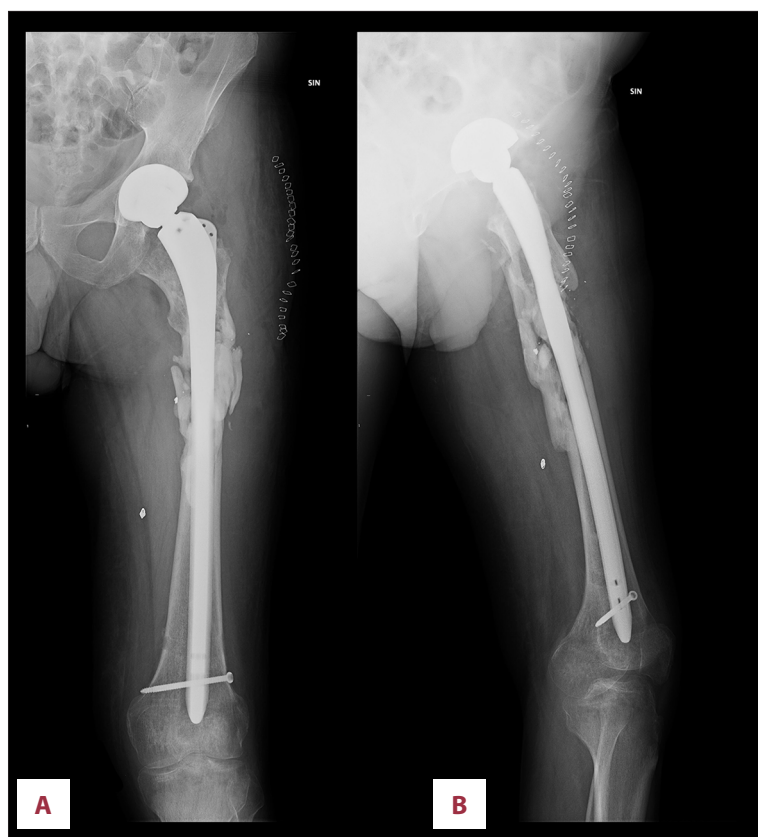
Cementless revision hip arthroplasty. X-rays (anteroposterior [A], lateral [B]) demonstrating hip arthroplasty with placement of an acetabular component (52 mm), a cementless revision femoral long stem (size +19, length 380 mm) with distal locking screw, and a 32-mm ceramic head.
